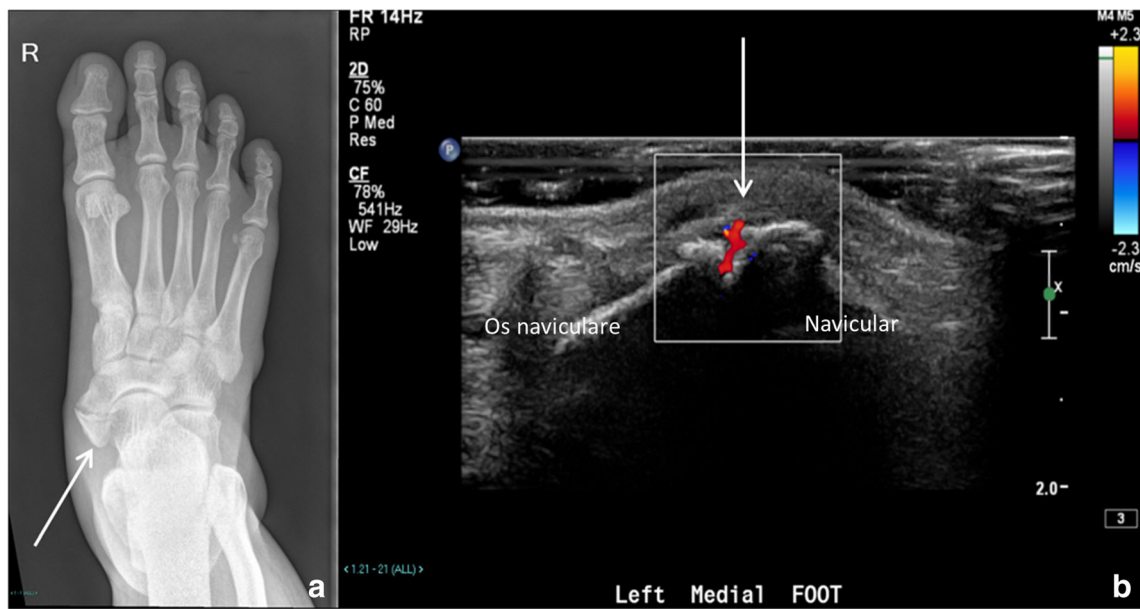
a, b Frontal radiograph of the right foot showed a type 2 accessory navicular and marginal osteophytic lipping across its synchondrosis. Targeted ultrasound over the medial aspect of the midfoot showed increased vascularity around the accessory navicular
